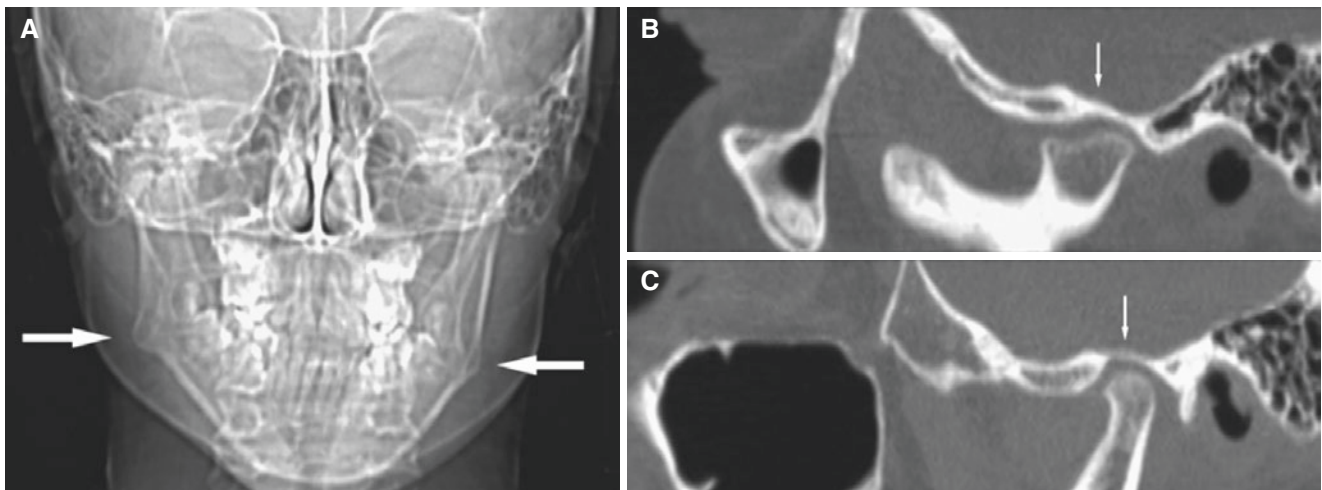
Facial asymmetry; 12-year-old female with a 4-year history of trauma to the chin but no fractures diagnosed. (A) Scout view shows facial asymmetry with mandibular underdevelopment on the right side (*arrows*). (B) Oblique sagittal CT image of right TMJ shows deformed
